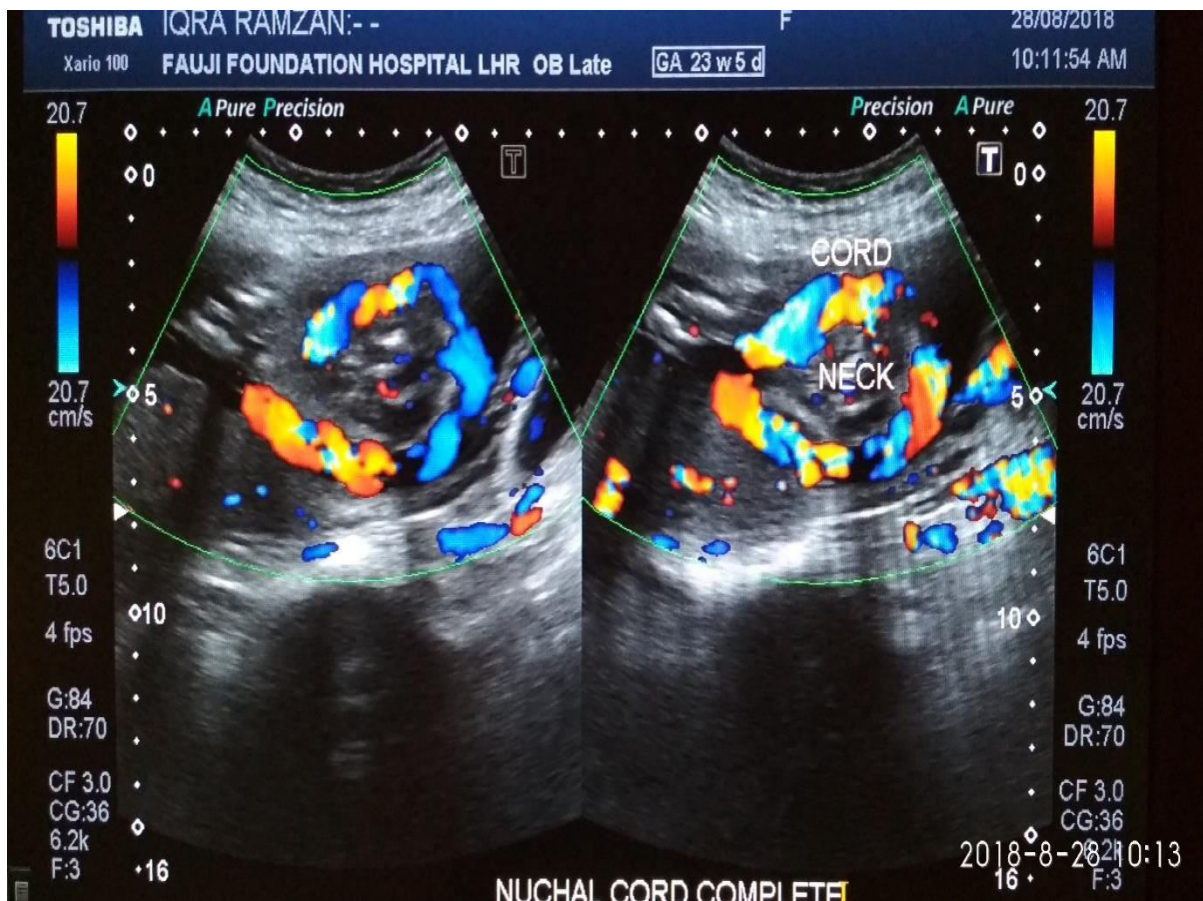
Fetal color doppler ultrasound of Tight Nuchal cord.
